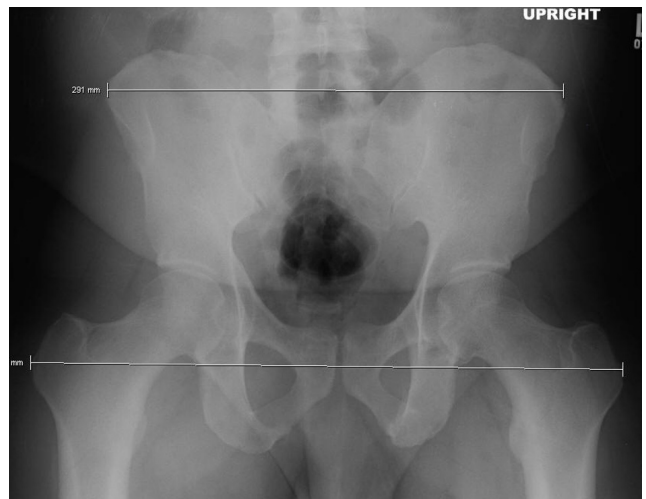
On same radiograph, Picture Archiving and Communication System measurements show 130% ratio of trochanter widths to iliac wing widths.
